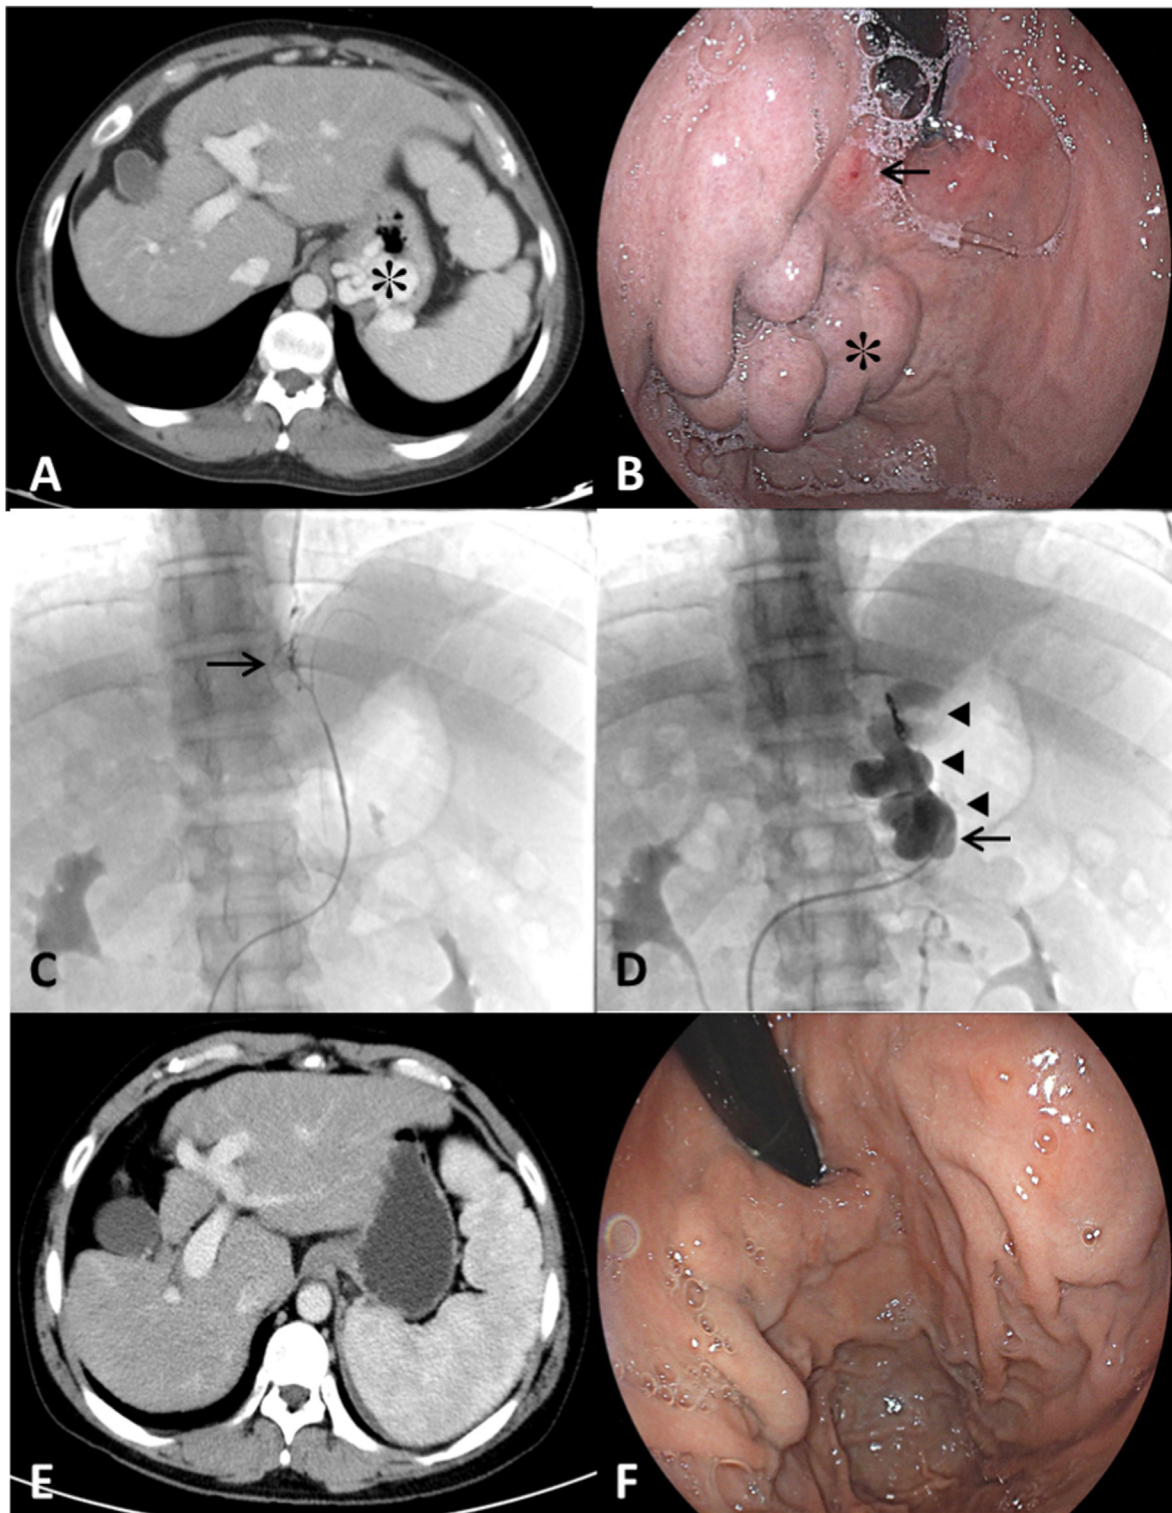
A 40-year-old man presented with hepatitis B cirrhosis and upper gastrointestinal bleeding. A. Enhanced abdominal computed tomography (CT) performed prior to balloon-occluded retrograde transvenous obliteration (BRTO) demonstrated isolated gastric varices in the stomach fundus (black star). B. Endoscopy performed before BRTO showed large isolated gastric varices at the fundus (black star). Red whale signs (black arrow) were visible on the varices, indicating a high risk of bleeding. C. The collateral vessels were embolized with microcoils (black arrow). D. Fluoroscopic image showing that the gastroduodenal shunt was occluded by a Fogarty balloon catheter (black arrow) and the varices filled with sclerosant foam (black arrowheads). E. Enhanced CT performed 1 year after BRTO showing complete variceal regression. F. Endoscopy performed 2 years after BRTO showing nearly complete variceal regression with a few small emerging collaterals.
